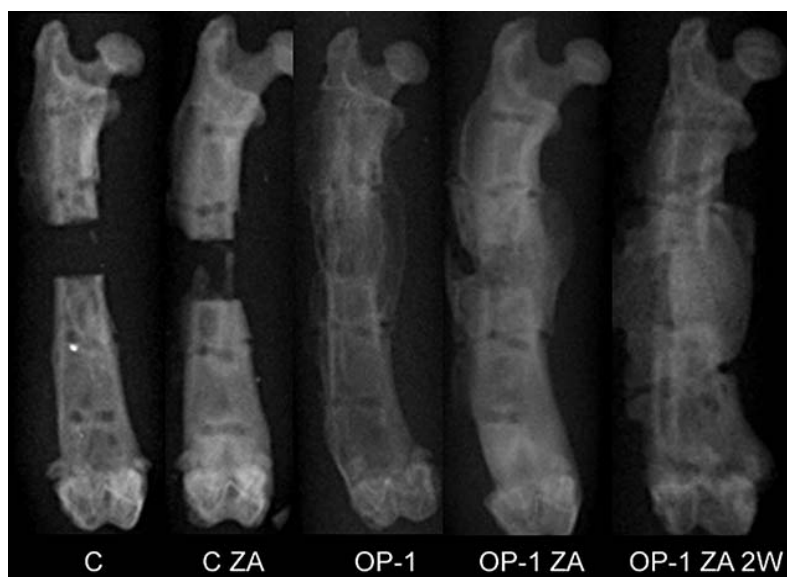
Radiographic X-rays demonstrating increased callus formation with co-treatment of rhBMP-7 (OP-1) and systemic zoledronic acid (ZA). Moreover, delaying systemic co-treatment to 2 weeks post-operatively led to further increased callus formation.
